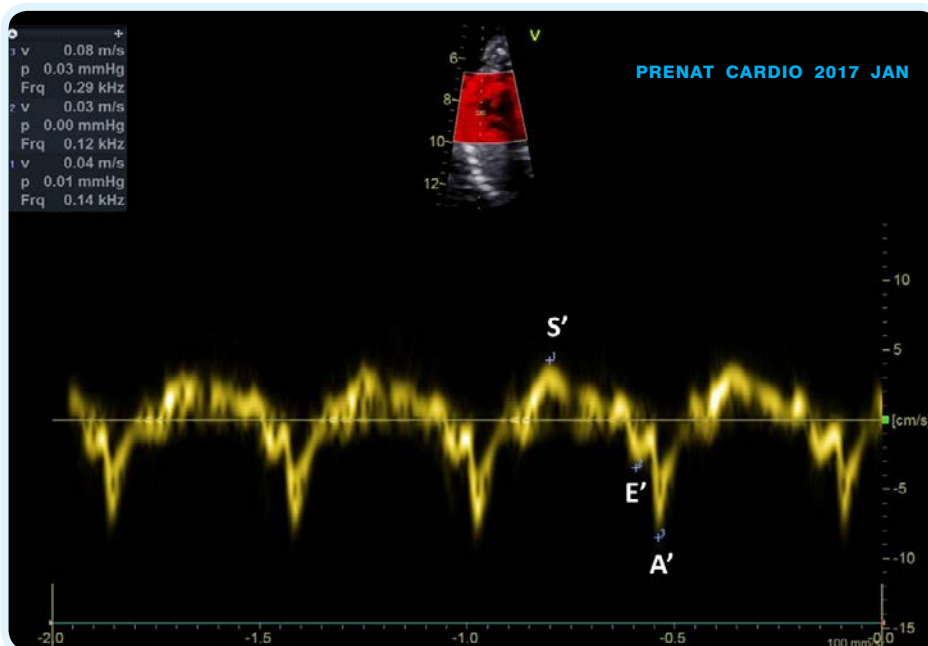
Tissue Doppler Imaging.
